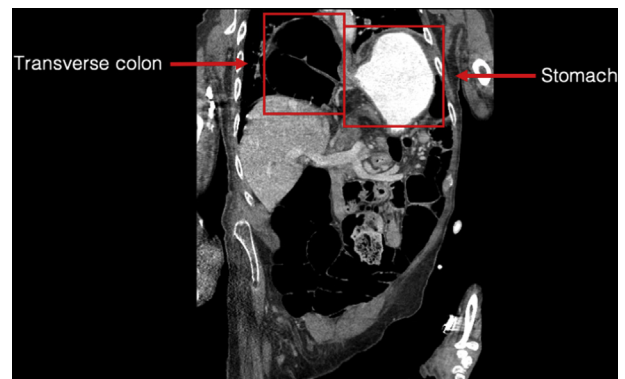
CT scan of the abdomen and pelvis showing a large right-sided Bochdalek hernia with superior displacement of the antrum and transverse colon into the chest through the diaphragmatic defect.
